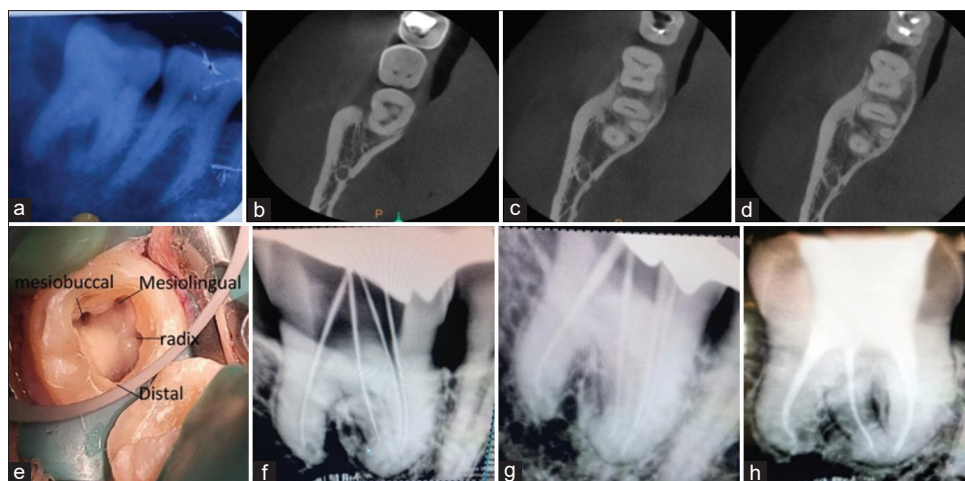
(a) Radiographic evaluation indicated deep dental caries extending close to the pulp, along with signs of periapical pathosis. (b-d) The axial CBCT slices, obtained at 180 μ m thickness, were examined at the cervical, middle, and apical thirds of the roots to assess canal morphology. (e) The cavity shape was modified from a triangular to a trapezoidal outline to accommodate the complex root canal anatomy. (f) The working length was determined. (g) Master cone radiograph. (h) Obturation and post-obturation radiograph
